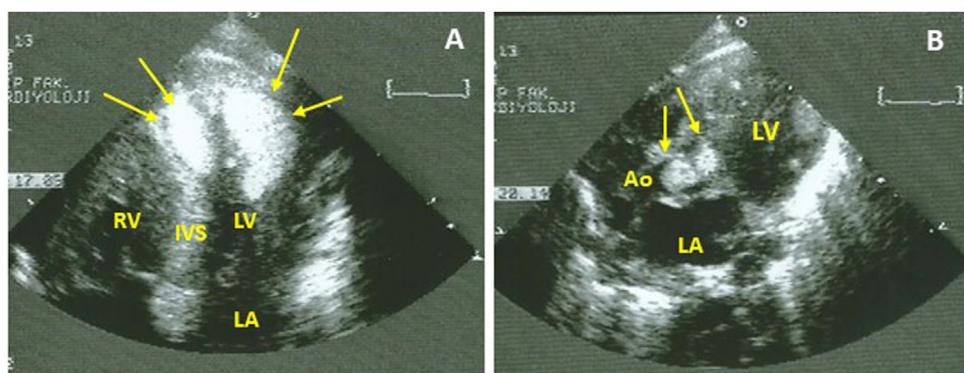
Transthoracic echocardiography demonstrated multiple rhabdomyomas with diameters of up to 16 mm (shown with arrows) in the left ventricular apex, IVS (A), and in LVOT which almost completely obstruct the aortic valve (B), in case 6. RV: right ventricle; LV: left ventricle; LA: left atrium; IVS: interventricular septum; Ao: aorta.
